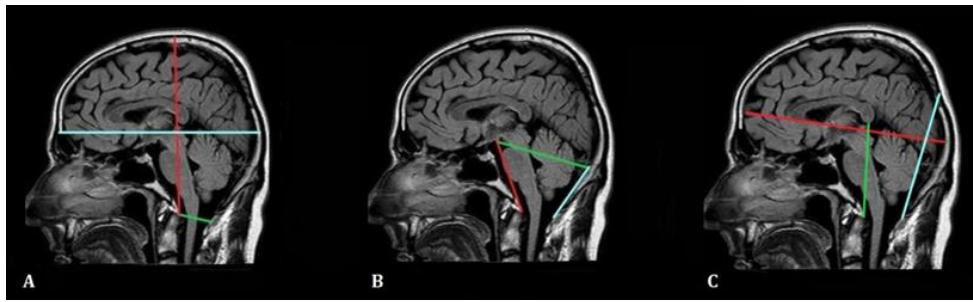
Sagittal FLAIR (A, B, C), an image demonstrating the distance measurements. (A) Maximum cranial length is shown by a blue line, maximum cranial height is depicted by a red line, foramen magnum sagittal diameter is shown by a green line. (B) Supra occiput length shown by a blue line, clivus length is depicted by a red line, posterior cranial fossa anteroposterior length is shown by a green line. (C) The occipital cord length is shown by a blue line, longest anteroposterior diameter of the cerebrum depicted by a red line, posterior height of the cranial fossa is shown by a green line.
